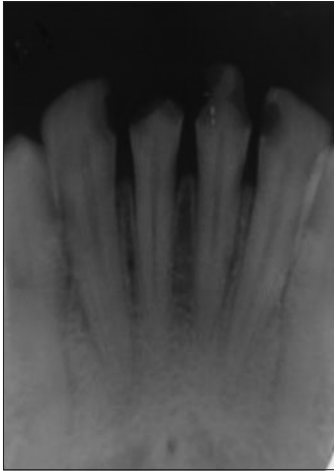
Intraoral periapical radiograph reveals caries involving pulp
